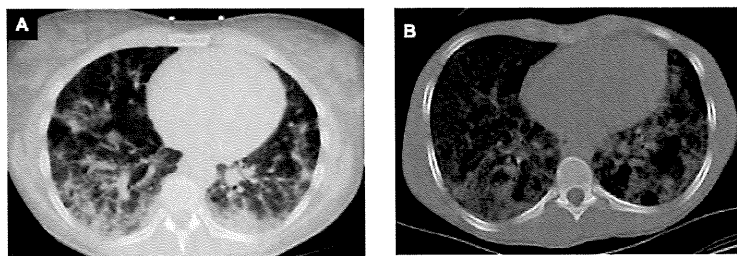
CT of the thorax from patients 2 (A) and 5 (B) that were obtained during hospitalization, showing bilateral pulmonary infiltrates
